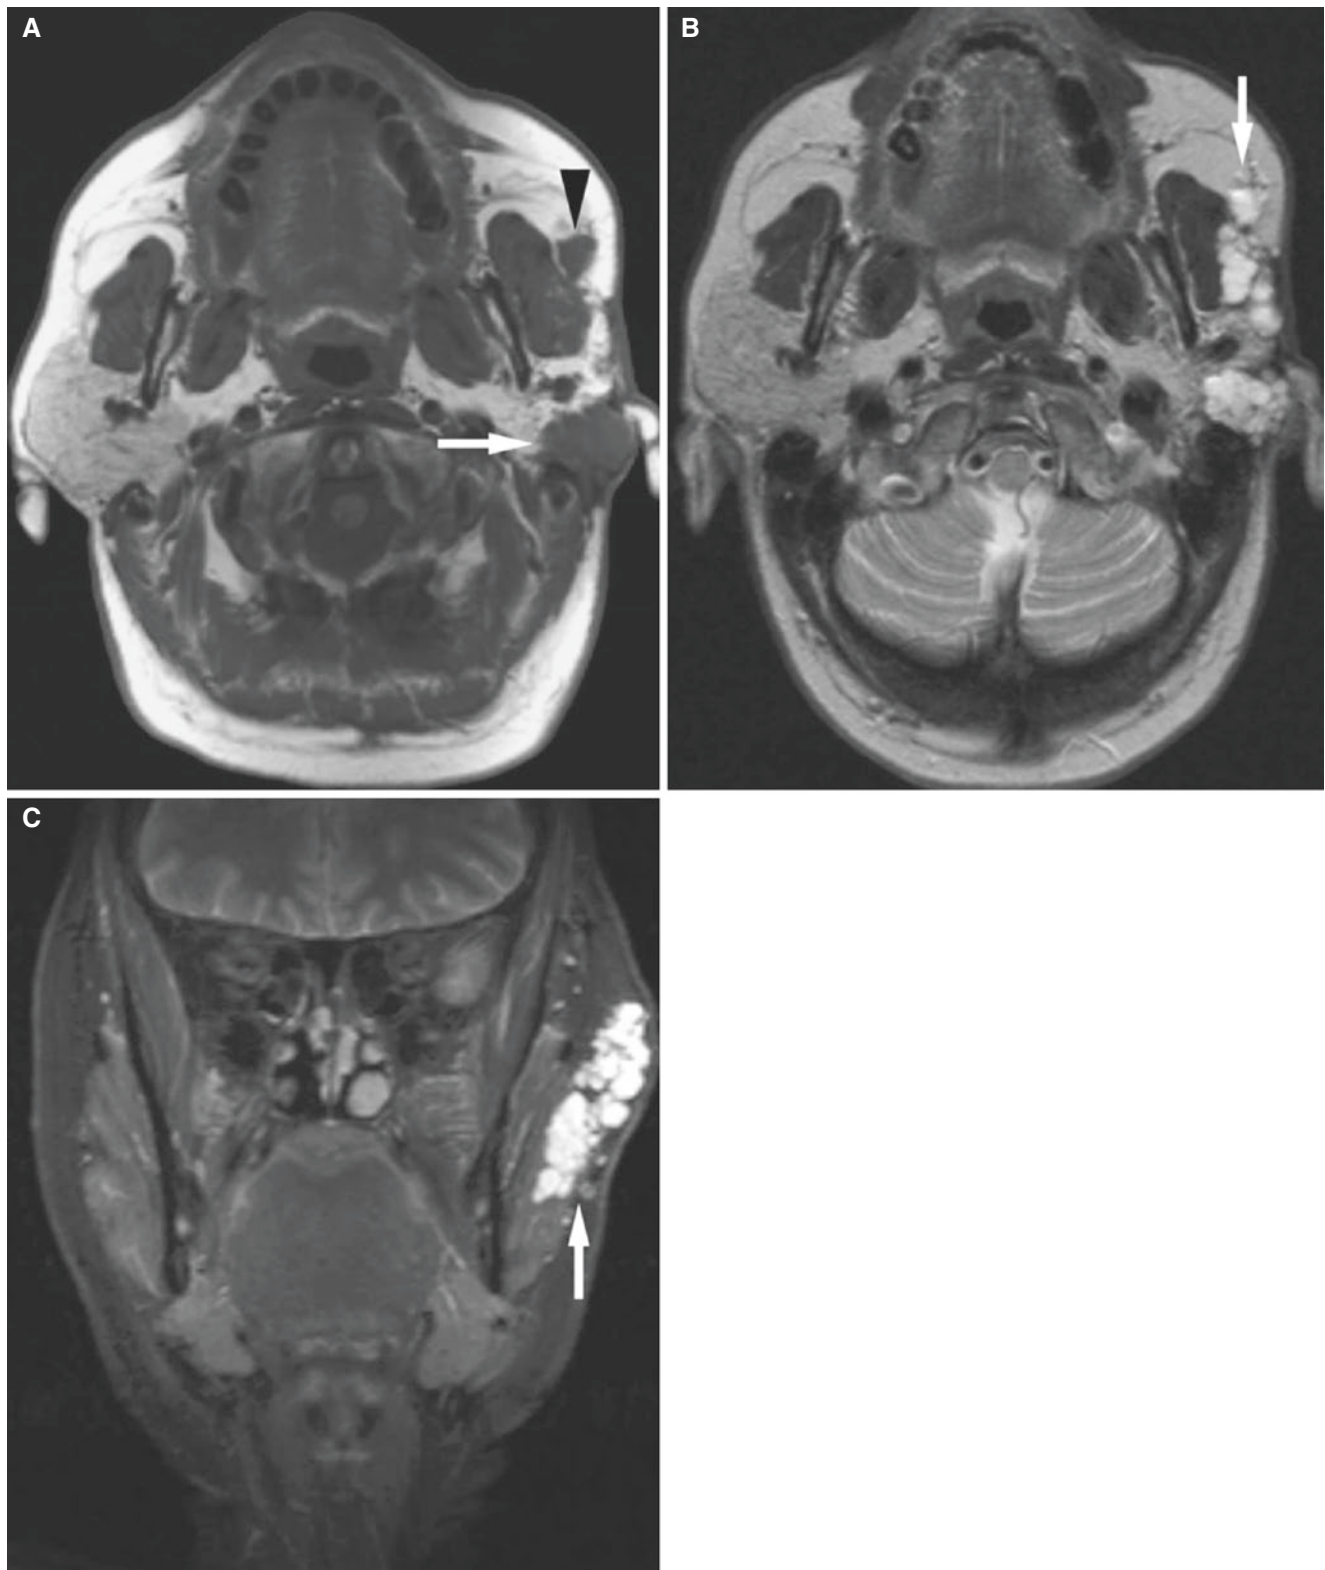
Parotid pleomorphic adenoma, superficial lobe; 61-year-old female with history of left parotid tumor surgery, now with multifocal recurrence. (A) Axial T1-weighted MRI shows low-signal mass in the posterior portion of the left parotid gland (*arrow*) and in accessory
